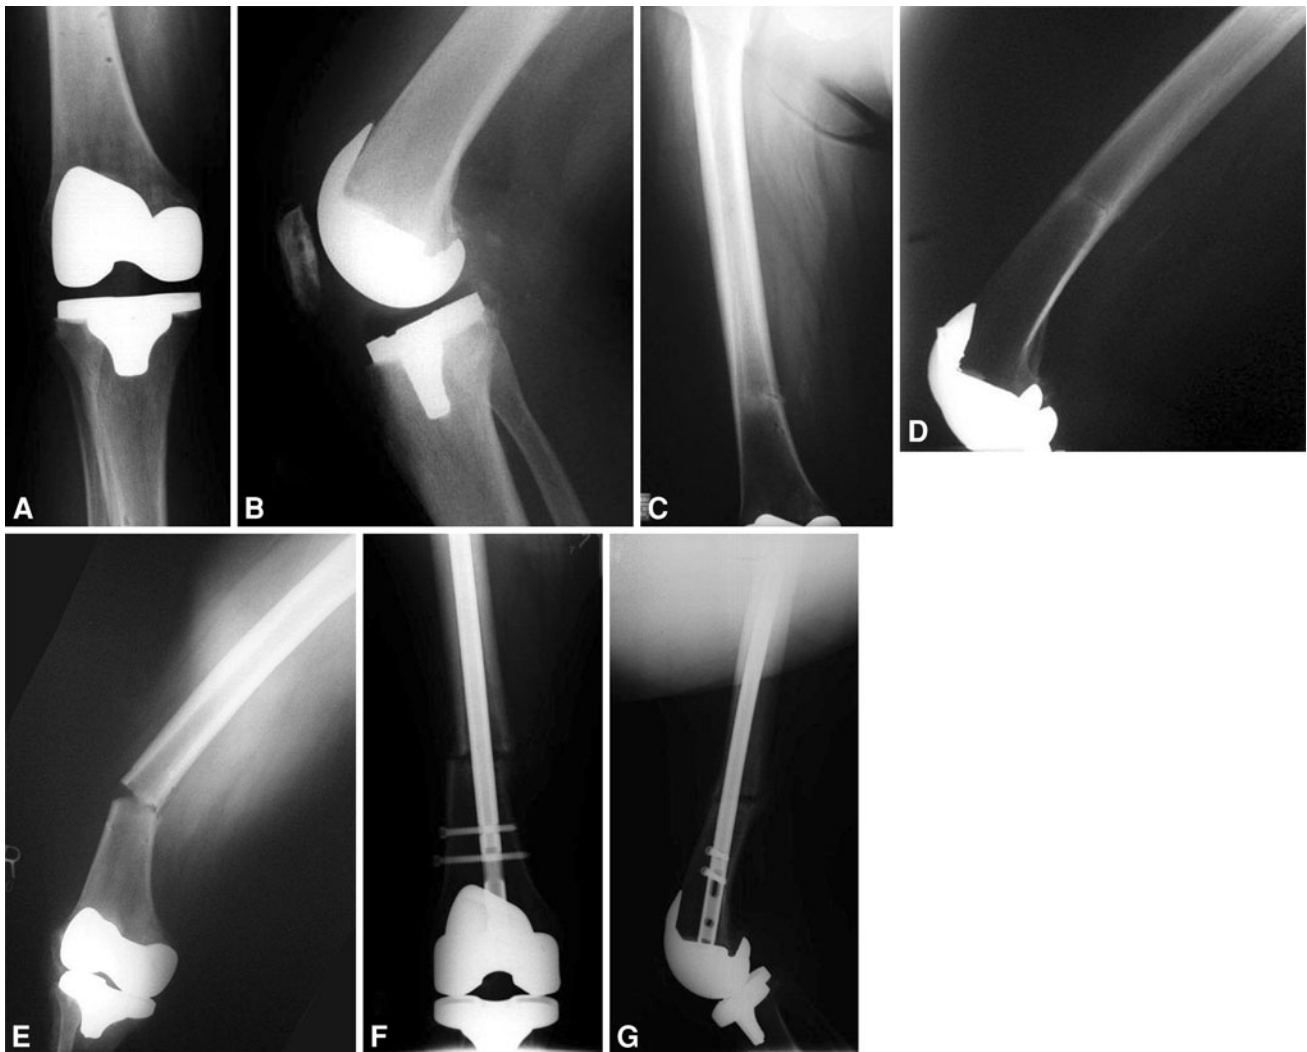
A 65-year-old woman presents at 6 months postoperatively with distal thigh pain; routine AP (A) and lateral (B) radiographs were performed. Longer leg femur films (C–D) demonstrate the distal
